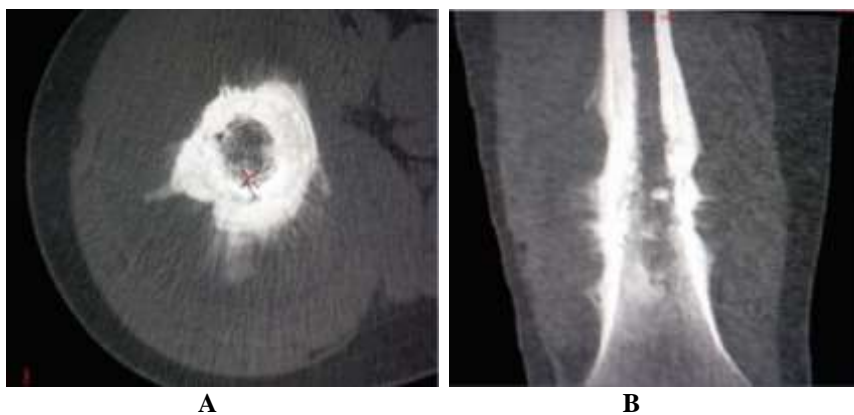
CT A) Axial & B) Coronal image shows aggressive, interrupted, sunburst/onionpeel periosteal reaction & codman’s triangle involving the femoral diaphysis with associated diffuse circumferential cortical thickening & obliteration of medullary cavity with soft tissue extension.
